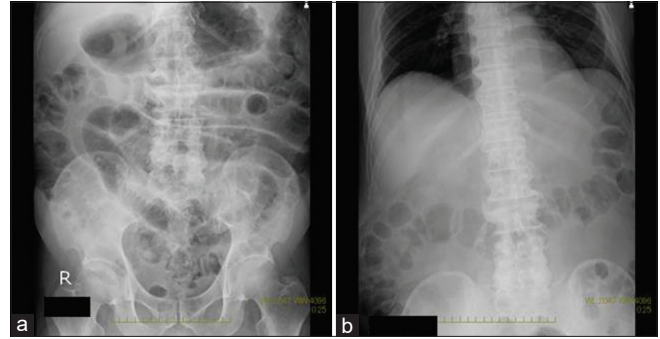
Plain abdominal radiographs 2 days after the operation (a) showing intestinal gas retention, which was improved by integrative treatment with Kampo medicines for 7 days (b).
